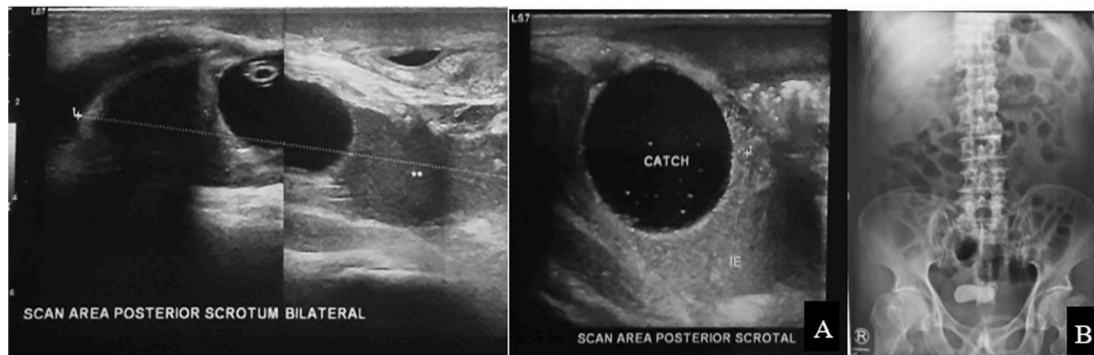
A) Scrotal ultrasonography. B) Kidney Ureter Bladder (KUB) x-ray.
